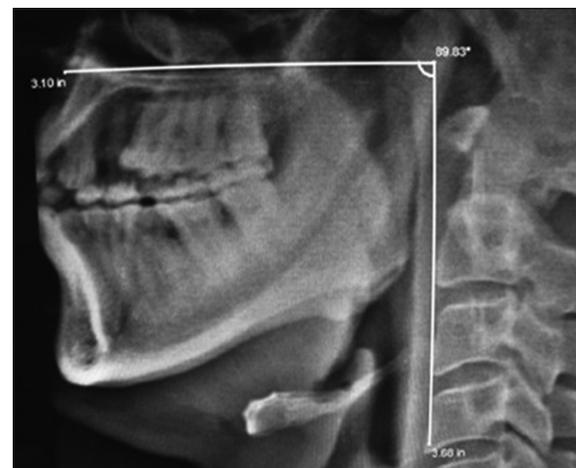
Radiographic measurement of MP angle
